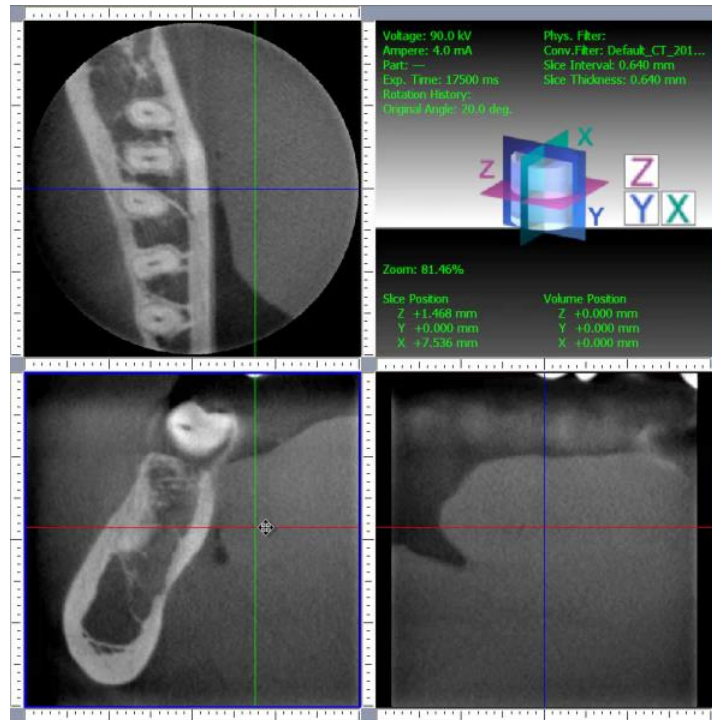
Selection of the CBCT slice that best confirmed the presence / absence of PA radiolucency in the sagittal, coronal and/or axial planes.
